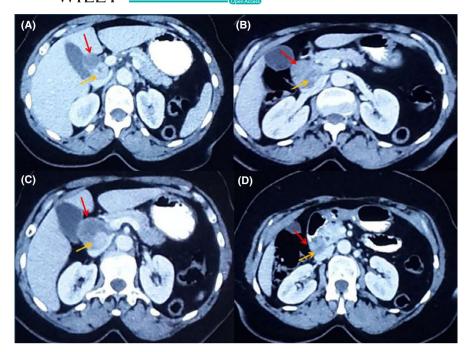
Abdominal CT images showing the mass (red arrow) and its extension to the inter-renal Inferior vena cava segment (yellow arrow)
